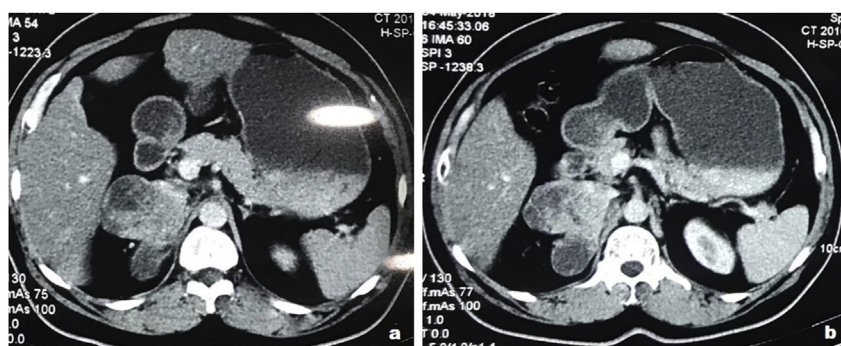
a & b. Computed Tomography (CT) imaging revealed a well-defined lobulated solid-cystic heterogeneously enhancing mass lesion in the right suprarenal region measuring 7.7× 6.9 × 8.8 cms.
